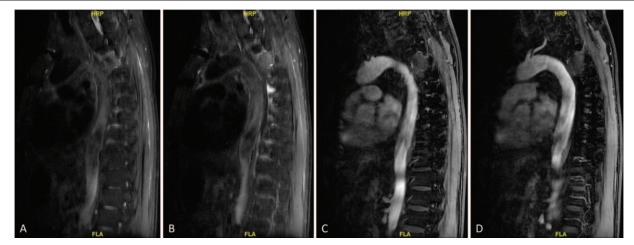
(A–D) Preoperative sagittal MRI scan revealing abnormal signal of T4 in keeping with diffuse metastatic infiltration caused by metastatic thymic carcinoma. MRI = magnetic resonance imaging.
